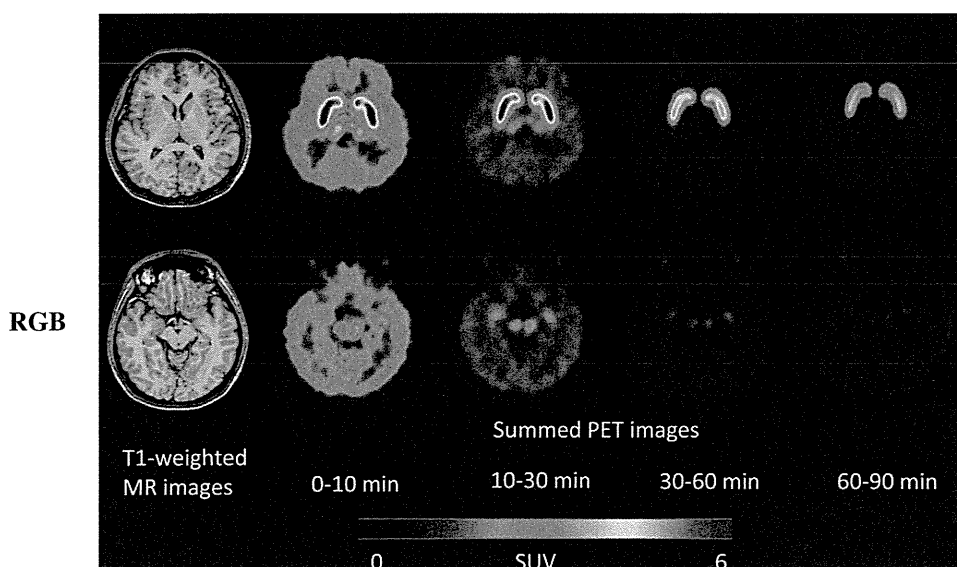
Representative dynamic PET images of healthy subject injected with ^{18}F -FE-PE2I. PET images were created at level of striatum (top) and midbrain (bottom). SUV = standardized uptake value.
